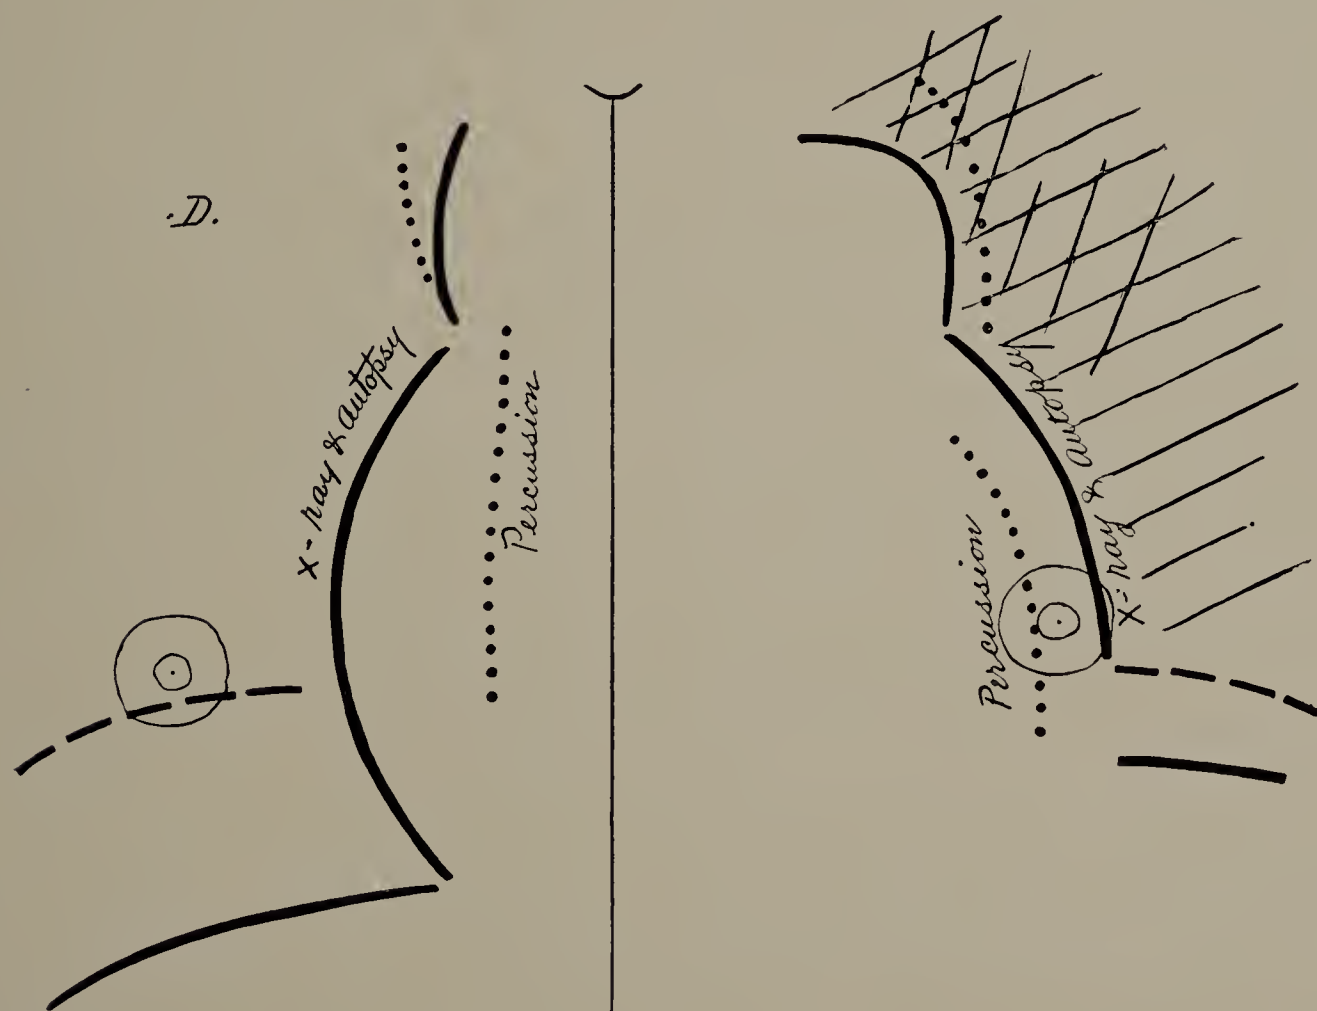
Case XIII. D. Aneurism of the ascending aorta without pulsation. X-ray and percussion lines compared. X-ray lines confirmed at autopsy ; also the density of the lung that was determined by X-ray examination. (Cut one-third life size.)
